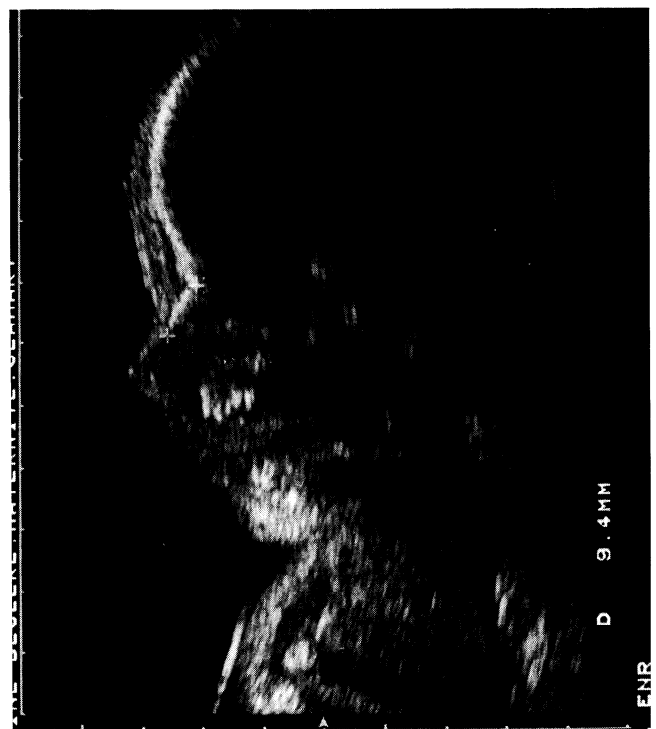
Ultrasound demonstration and measurement of length of nasal bones on a strictly medial sagittal plane
